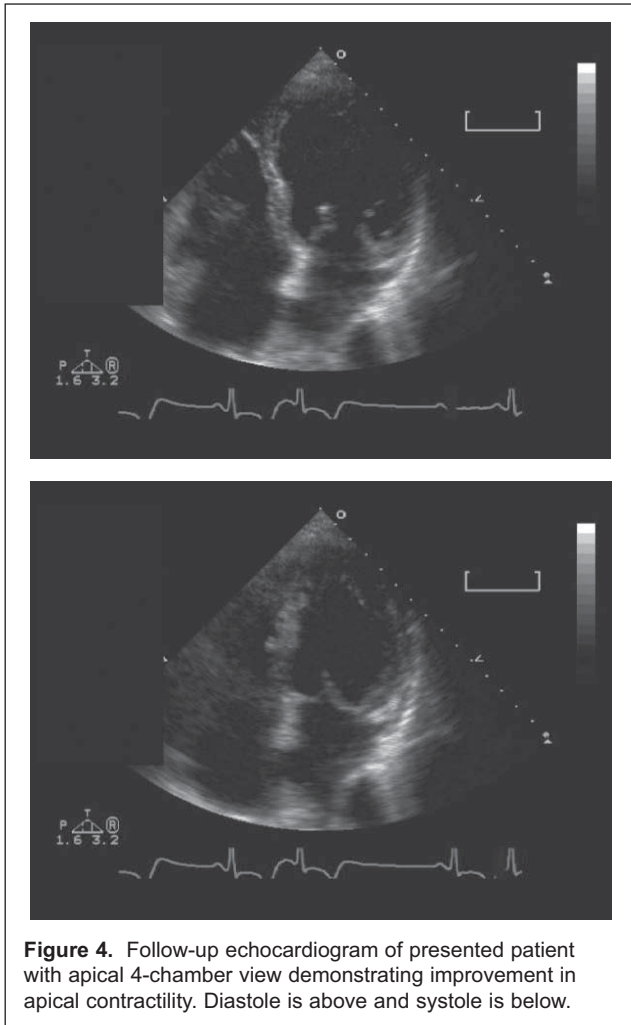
Follow-up echocardiogram of presented patient with apical 4-chamber view demonstrating improvement in apical contractility. Diastole is above and systole is below.
